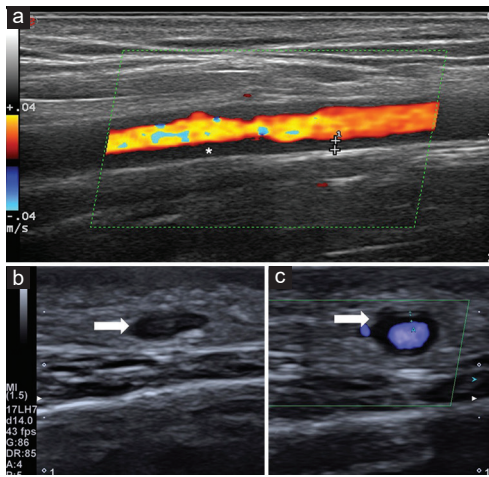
Typical color Doppler sonography findings in cranial giant cell arteritis. Halo sign around the temporal artery on longitudinal view (white asterisk, a) and transverse view (white arrows b and c). The halo sign indicates inflammation of the vessel wall and remains visible after compression of the vessel (b)
